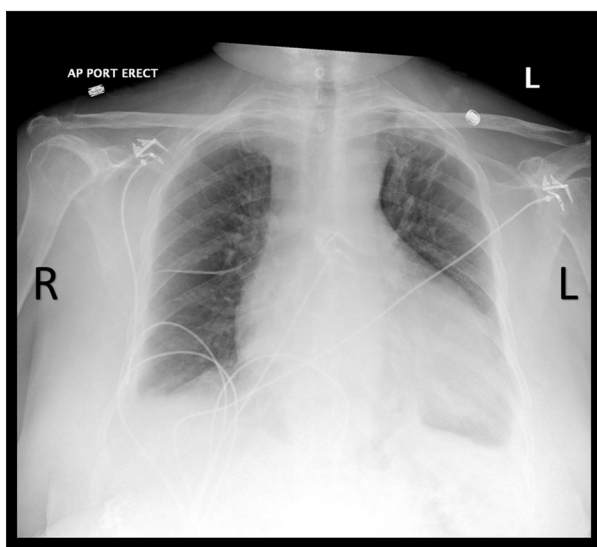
Chest X-ray following treatment with trimethoprim-sulfamethoxazole (TMP-SMX).
